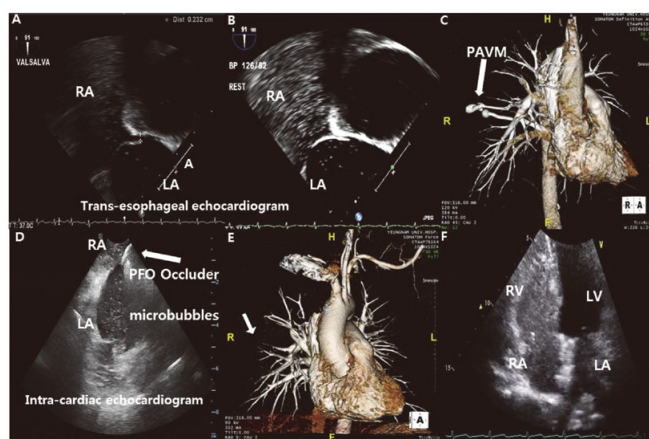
(A) TEE with agitated saline test during Valsalva maneuver. (B) TEE after 5 cardiac cycles of agitated saline infusion. (C) PAVM on 3D-CTPA (white arrow). (D) Intra-cardiac echocardiogram with agitated saline test after PFO closure (white arrow). (E) Disconnection of PAVM on 3D-CTPA after coil embolization (white arrow). (F) Transthoracic echocardiography with agitated saline test after closure of both PFO and PAVM. PAVM, pulmonary arteriovenous malformation; PFO, patent foramen ovale; TEE, transesophageal echocardiogram; 3D-CTPA, 3D-computed tomographic pulmonary angiography.
